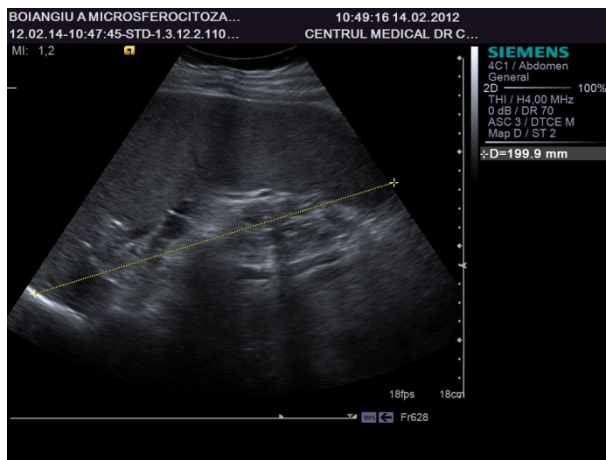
Ultrasonography showing splenomegaly.
